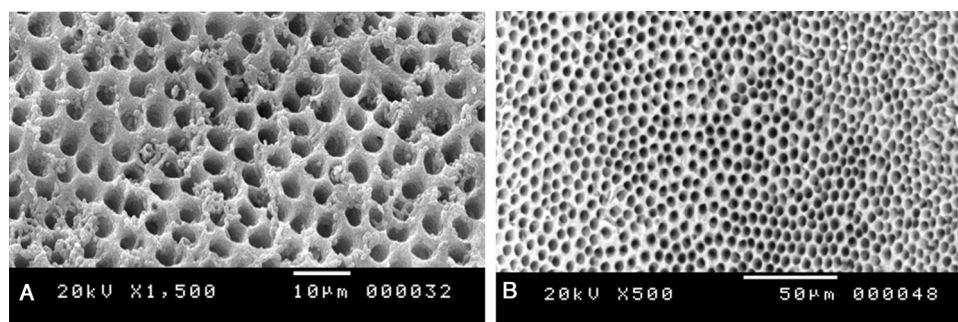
(A) Root canal surface after LED treatment (72 h): some isolated groups of bacteria are still present on the root canal surface and into the dentinal tubules. The biofilm is partially disrupted. (B) Root canal surface after PUI treatment (72 h) (NaOCl and EDTA): Root canal walls are clean. There was no more biofilm or microorganism after using EDTA and NaOCl irrigation solutions, and ultrasonic activation.
